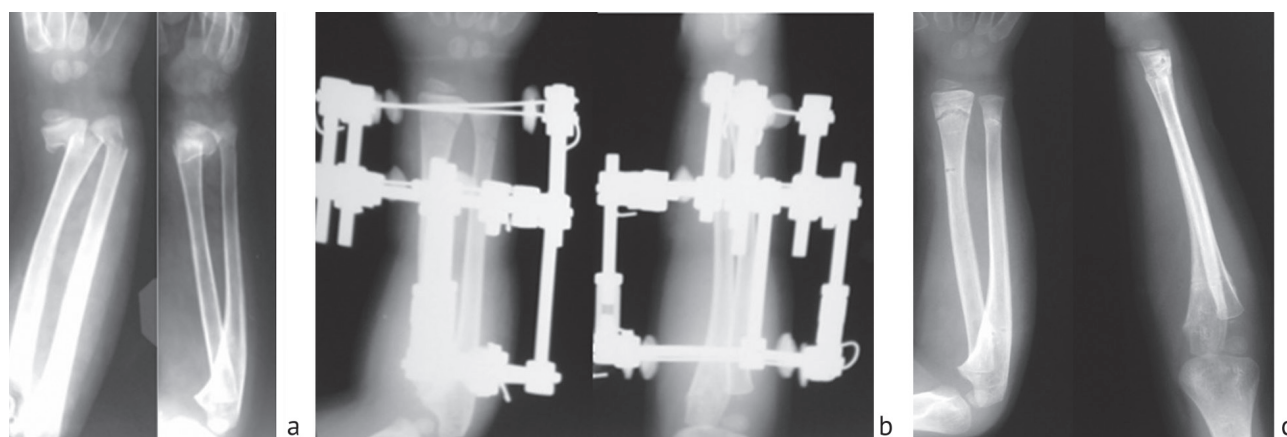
Closed fracture of the distal metaphysis of the forearm (SH II). Radiographs of the fracture area taken in two projections: *a* before the operation; *b* after osteosynthesis according to Ilizarov; *c* after dismantling the Ilizarov apparatus
